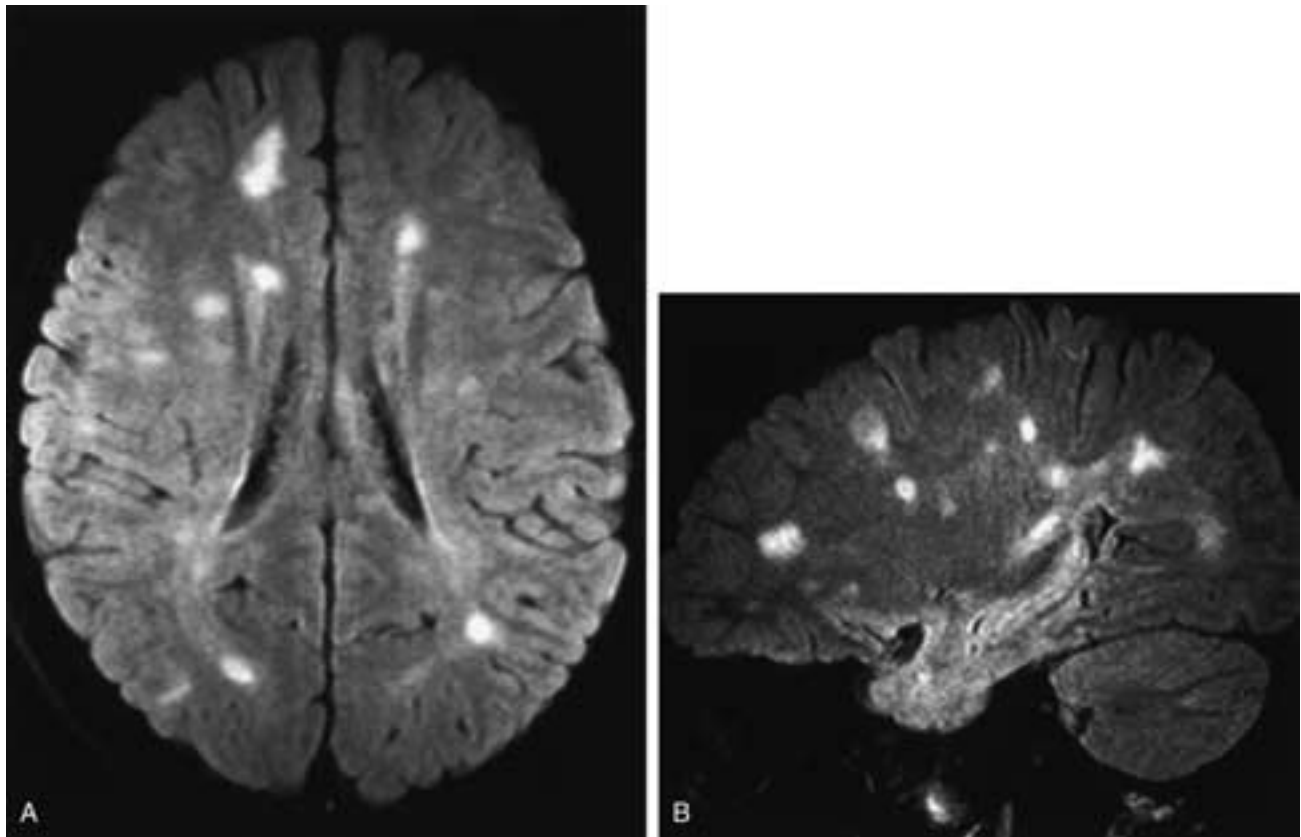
Multiple sclerosis. A and B, Axial and sagittal FLAIR images show multiple high-intensity multiple sclerosis plaques.
